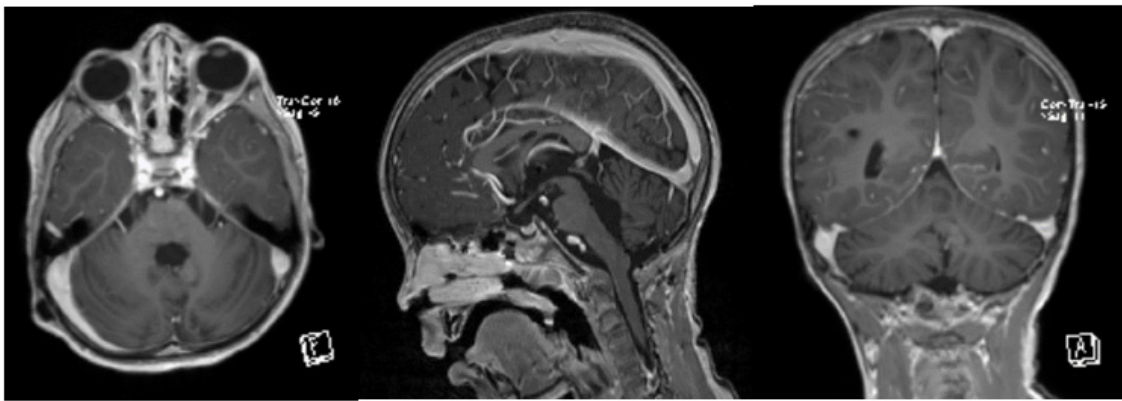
MRI 1 year post-operative: No residual.
